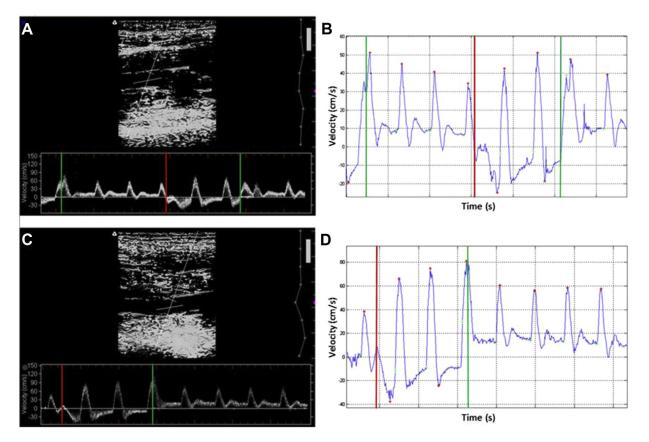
Representative samples of (A and C) ultrasound/Doppler recordings and (B and D) corresponding digitalization (B and D) of limb hemodynamics during (A and B) high-frequency and (C and D) low-frequency intermittent pneumatic compression (IPC) treatment. The *red lines* indicate cuff inflation, and the *green lines* indicate cuff deflation. Note the oscillatory shear that occurs during cuff deflation during each respective treatment frequency. Importantly, high-frequency IPC doubles the proportion of each minute the limb is exposed to this state of oscillatory shear but has no acute detrimental effect on popliteal artery function. Figure adapted from Sheldon et al.⁵
